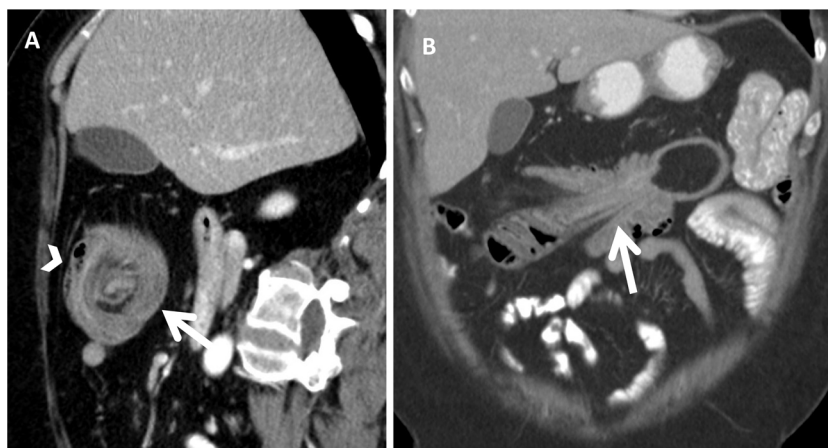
Computed tomography. A) Transverse view of intestinal intussusception; a “target” or “doughnut” image can be seen (arrow) with a lipoma in its centre, as well as mesenteric vessels and fat in the periphery (arrowhead). B) Longitudinal view of the intussusception; the colon can be seen with thickened walls and mesenteric fat and vessels entering the intussusception.
